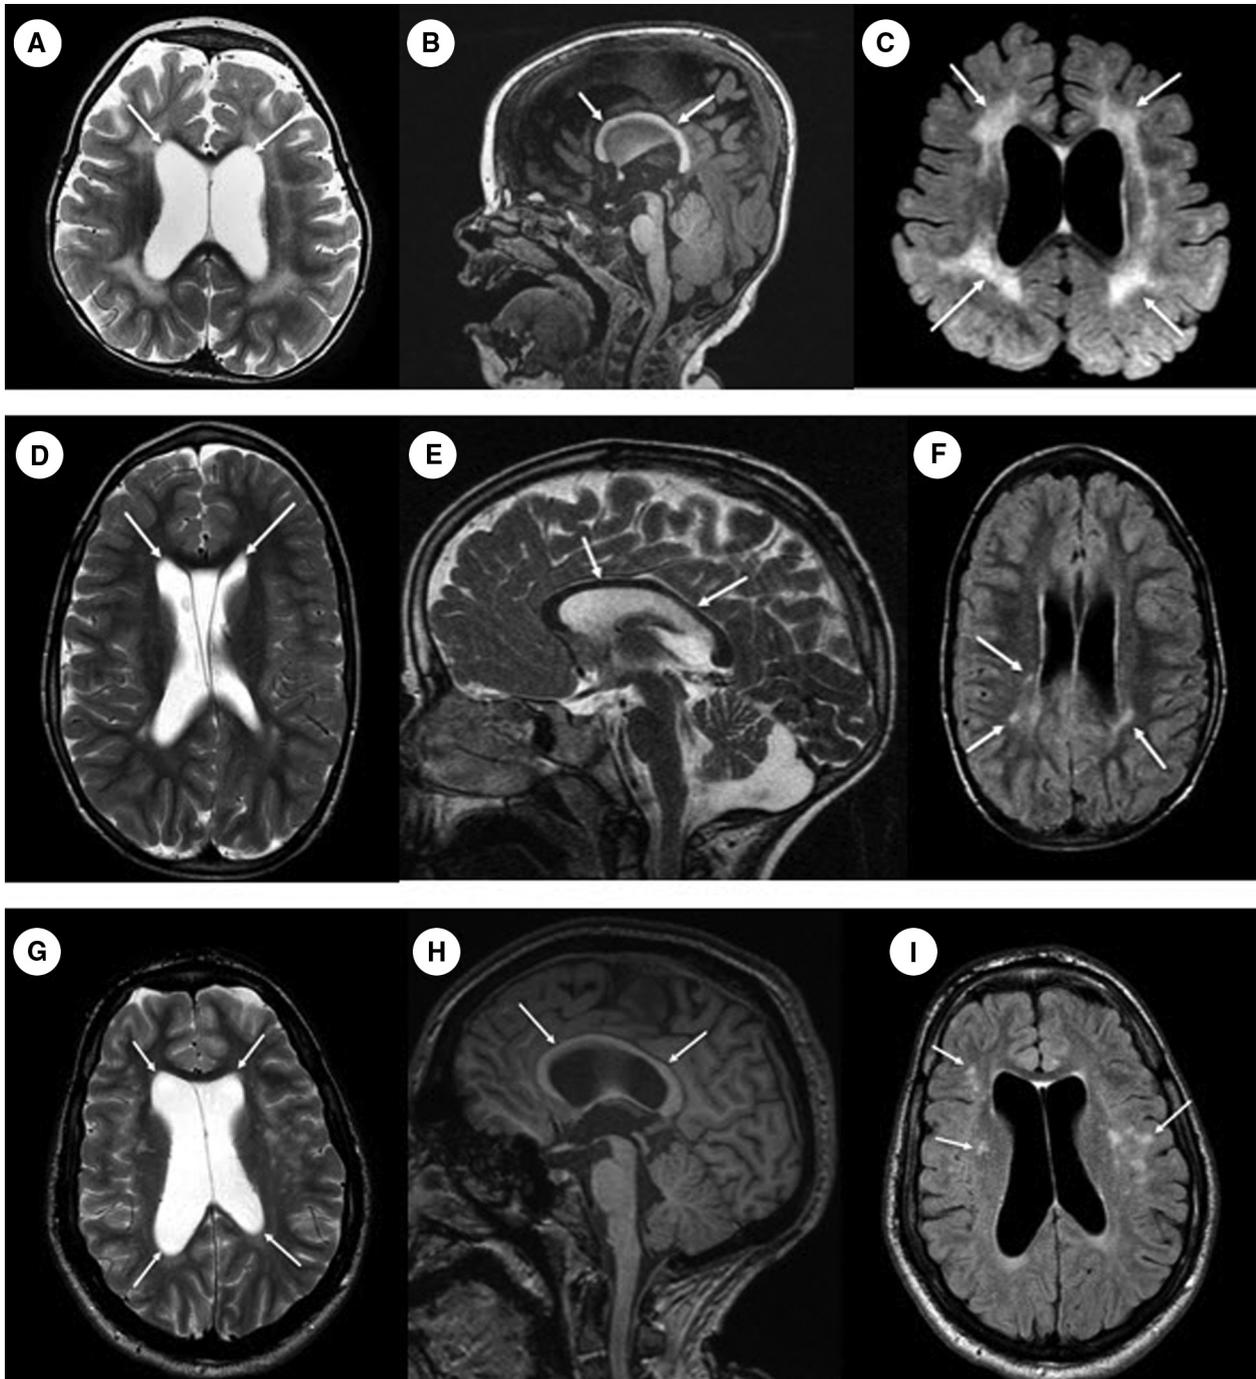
Brain magnetic resonance images from three different patients with congenital myotonic dystrophy. The first patient (A–C) is a 20-month-old female with decreased white matter volume marked by moderate ventriculomegaly of the lateral ventricles on T2 (A, arrows) and associated thinning of the corpus callosum seen on sagittal T1 (B, arrows). There is asymmetric confluent T2/ fluid-attenuated inversion recovery (FLAIR) hyperintense signal in the periventricular white matter (C, arrows). The second patient (D–F) is a seven-year-old male with milder intracranial findings with mild ventriculomegaly of the lateral ventricles on T2 (D, arrows) and associated thinning of the corpus callosum on sagittal T2 (E, arrows). There are a few foci of T2/FLAIR hyperintense periventricular white matter signal (F, arrows). The third patient (G–I) is a 22-year-old male also with mild ventriculomegaly of the lateral ventricles on T2 (G, arrows) with associated thinning of the corpus callosum on sagittal T1 (H, arrows). There are several T2/FLAIR hyperintense foci on FLAIR (I, arrows) in the left greater than right deep and subcortical white matter.
